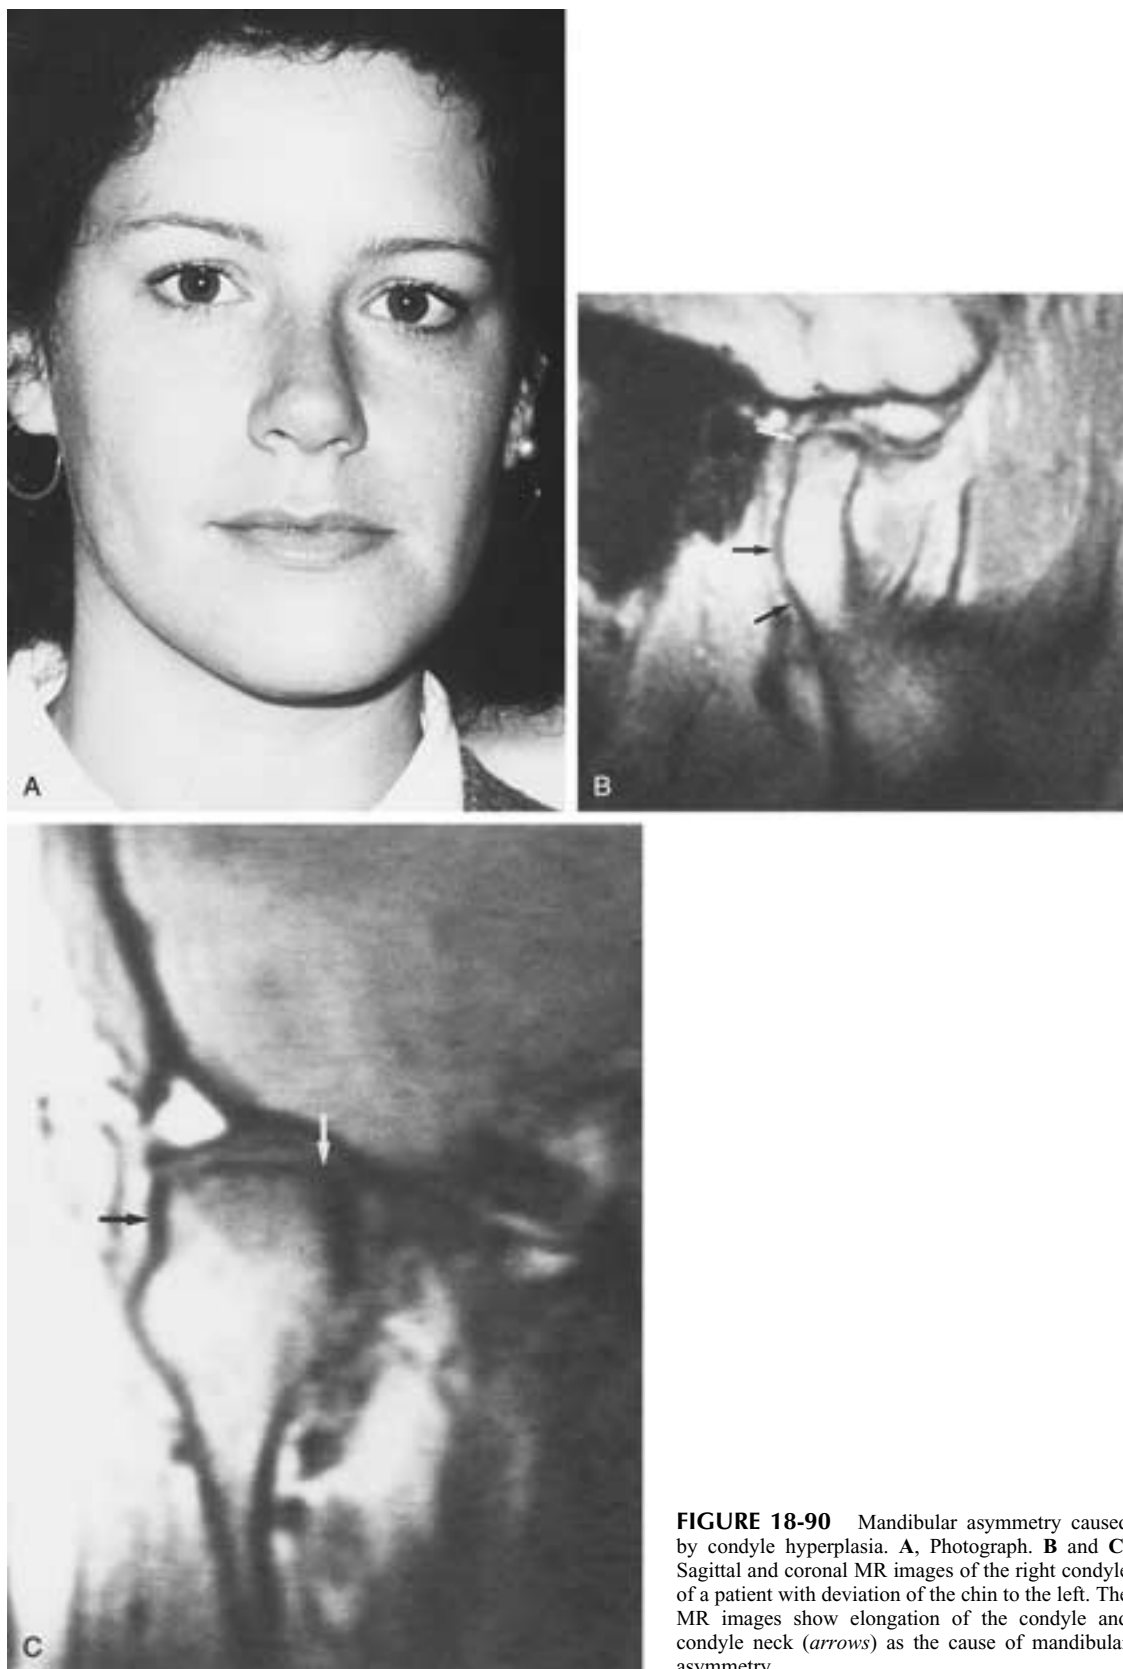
Mandibular asymmetry caused by condyle hyperplasia. A, Photograph. B and C, Sagittal and coronal MR images of the right condyle of a patient with deviation of the chin to the left. The MR images show elongation of the condyle and condyle neck (*arrows*) as the cause of mandibular asymmetry.
